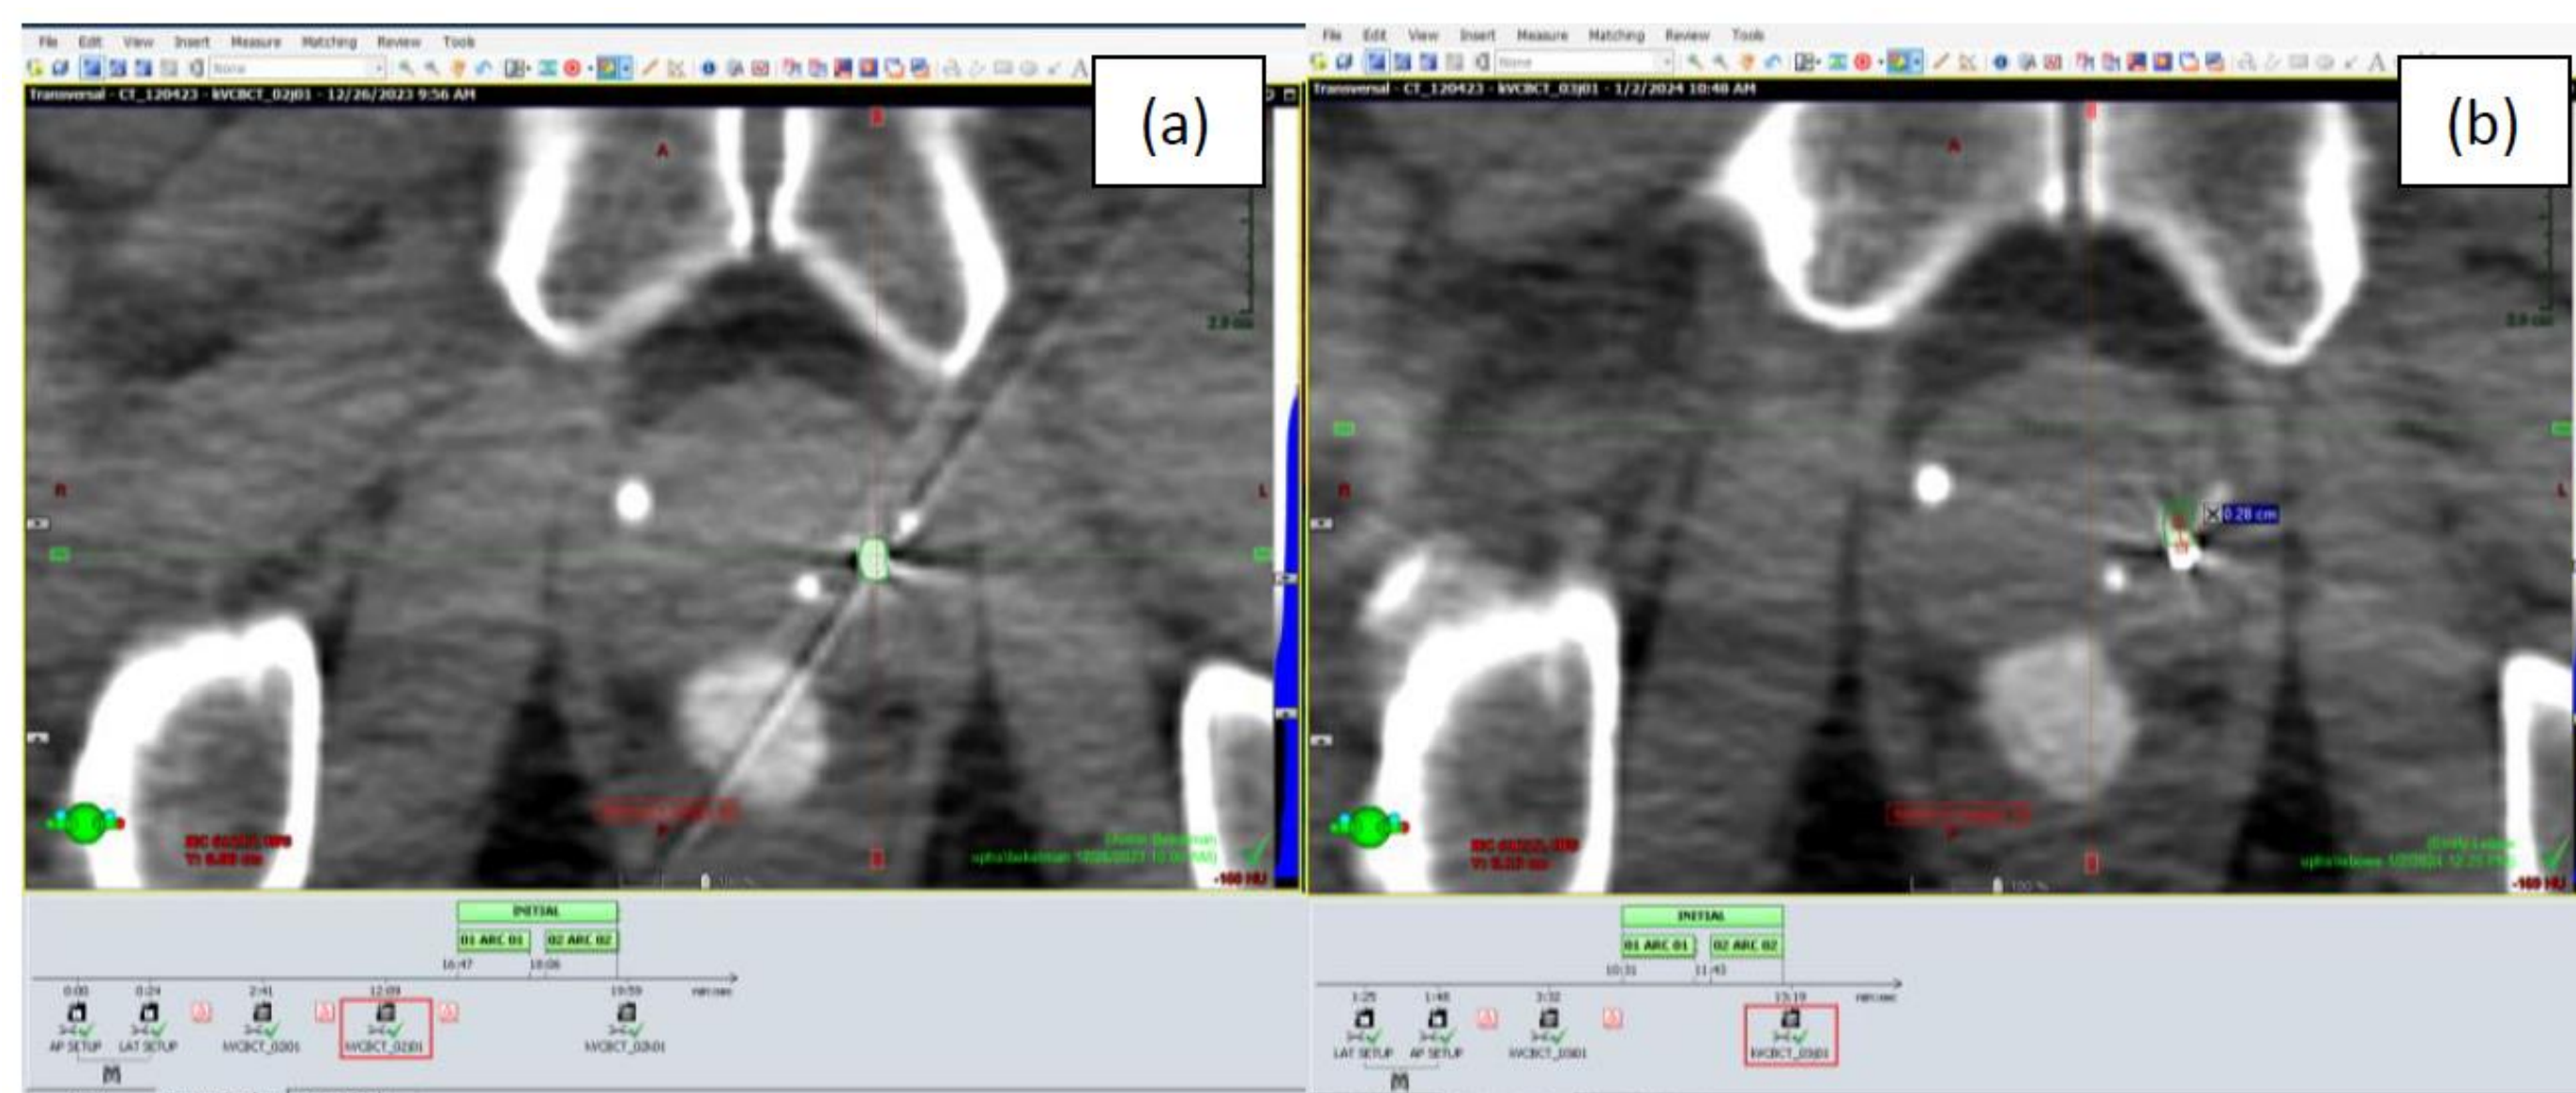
The fiducial drift can be measured by comparing (a) pre-treatment and (b) post-treatment CBCTs.
